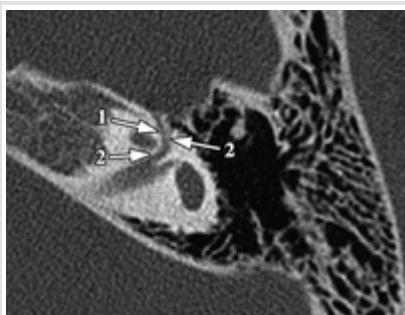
Transverse multi-detector row CT scan of a left temporal bone with variation of the facial nerve canal. Canal of the greater superficial petrosal nerve (1) emerges in the proximal S1 segment of the facial nerve canal (2).
